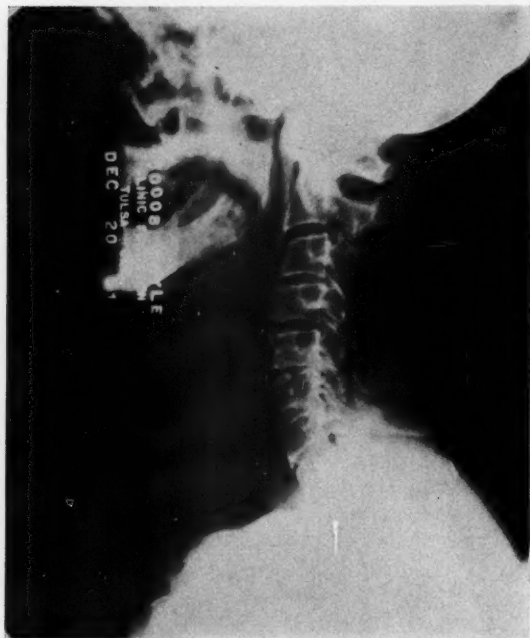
Roentgenogram showing narrowing of fifth and sixth cervical interspaces with osteoarthritis in a cervical disk case.
